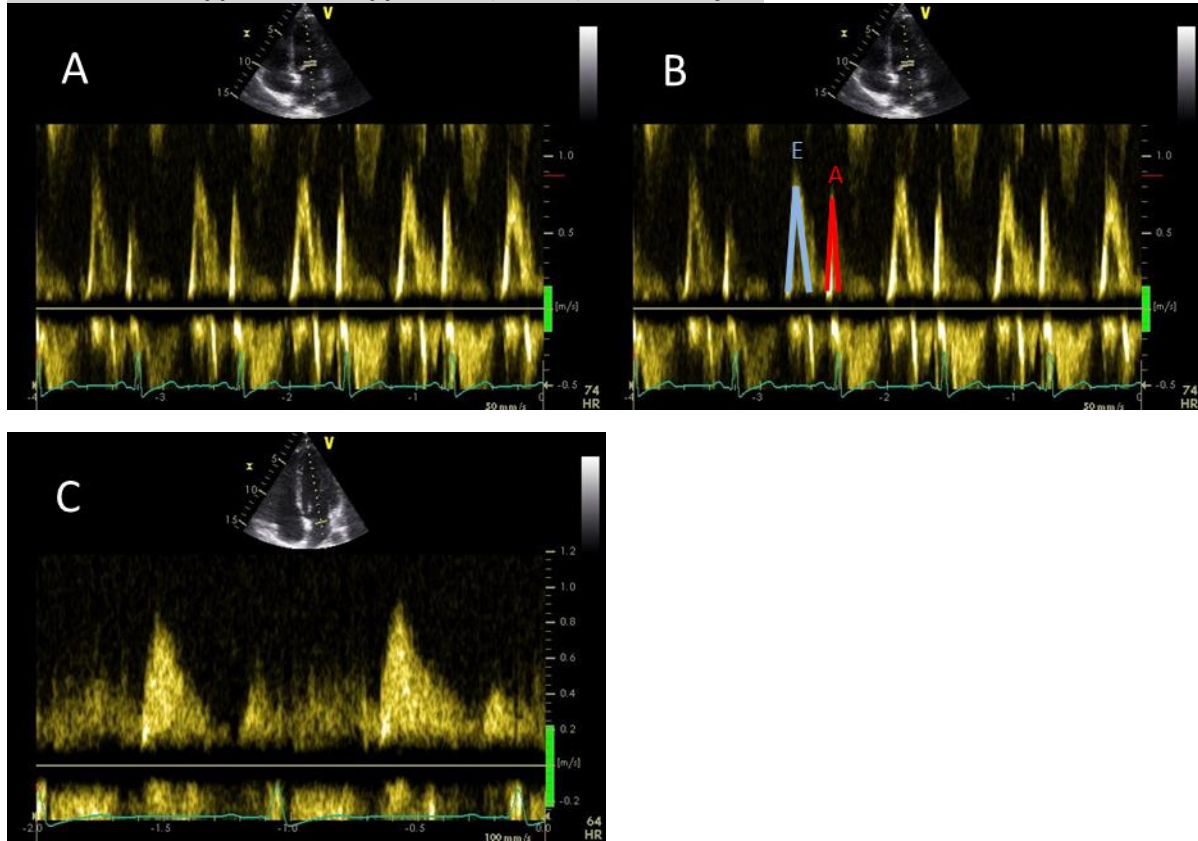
PW Doppler of mitral valve without measurement (A), with measurement (B), CW Doppler of mitral valve (C) (in order to detect high velocities to exclude mitral stenosis)
